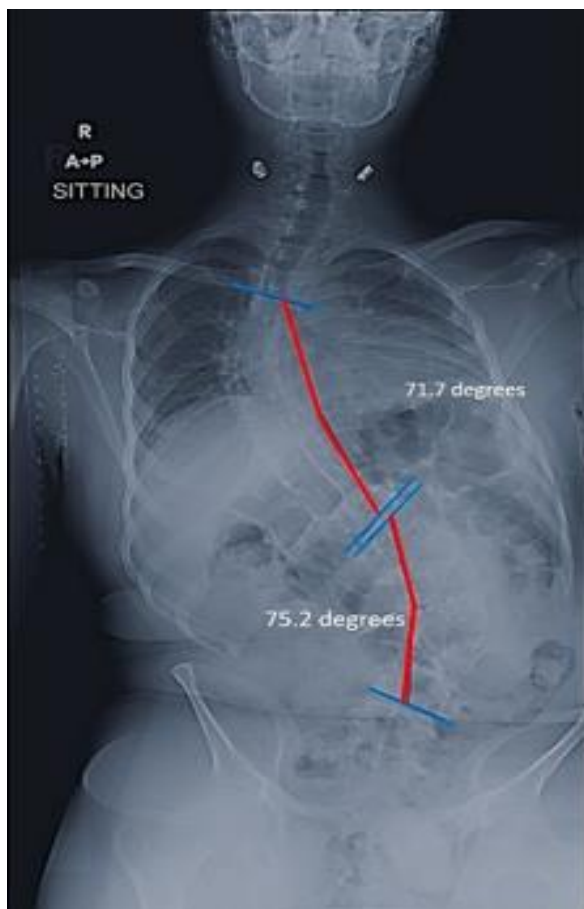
Plain radiograph (sitting) antero-posterior view of whole spine of a boy with Friedreich's ataxia showing double major curve - right thoracic scoliosis with 71.7 degrees and left lumbar curve with 75.2 degrees (Figure 2) and right costo pelvic impingement
